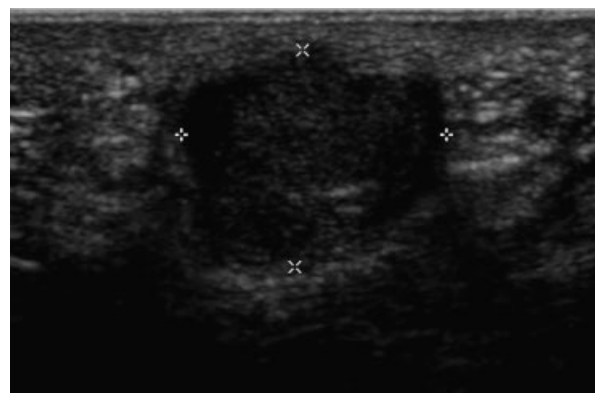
Ultrasonography showing a round, well-demarcated, irregular echogenic mass under the dermis.
